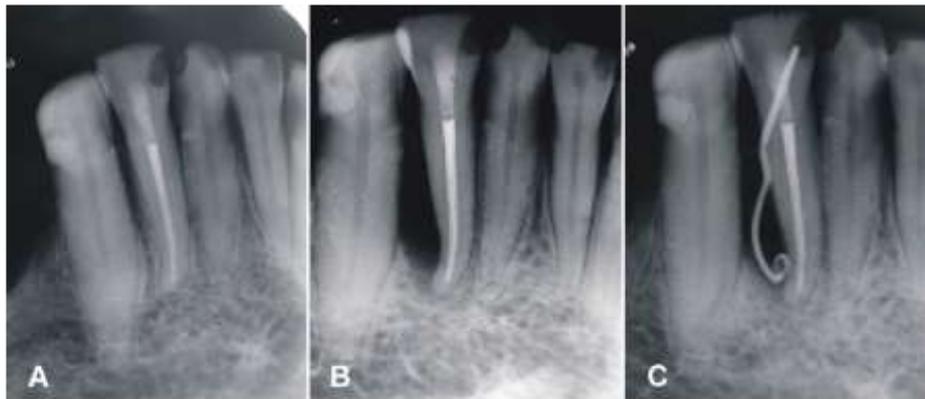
Radiographical features of Vertical root fracture. (A) Quality of root canal filling immediately after endodontic therapy. (B) Distal radiolucent image of tooth. (C) Mapping of sinus.
